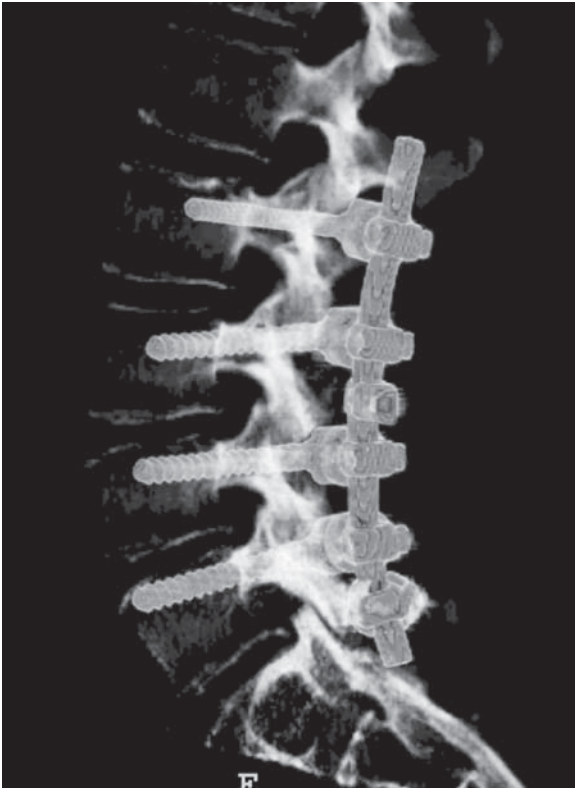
Computed tomography three-dimensional reconstruction of lumbar spine following posterior spinal fusion. (Courtesy of Philips Medical Systems, Bothell, WA.)
